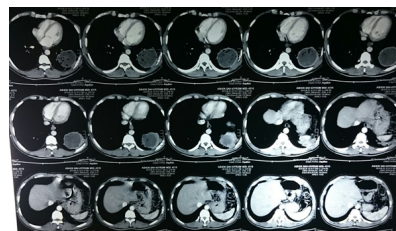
Contrast enhanced computed tomography of chest show left lung large hydatid cyst lesion.
